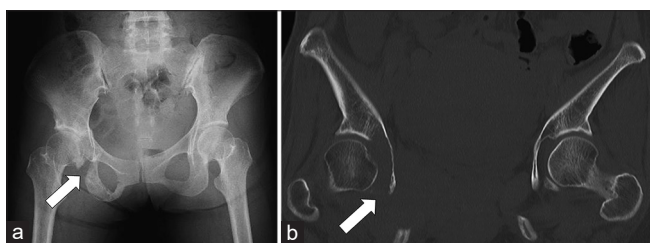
X-ray and computed tomography (CT) image after delivery. (a) X-ray revealing a lytic lesion in the acetabulum. (b) CT image indicating a fracture of the ischium
